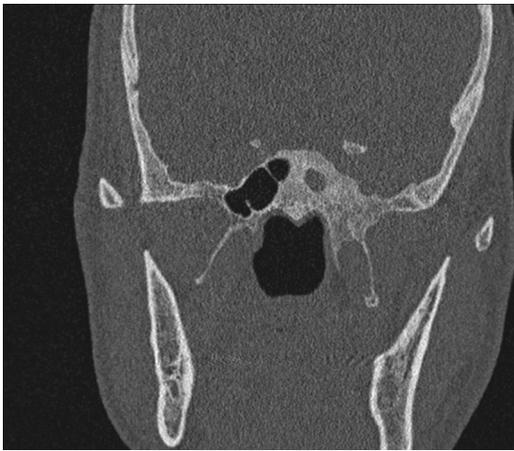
Computed tomography, coronal section, showing osteosclerosis of the left sphenoid bone.
